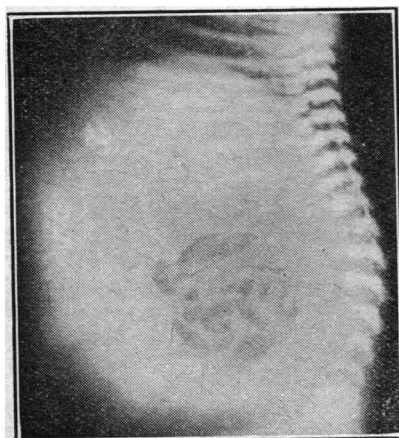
Case 1. Lateral radiograph taken when patient was 5 hours old.
